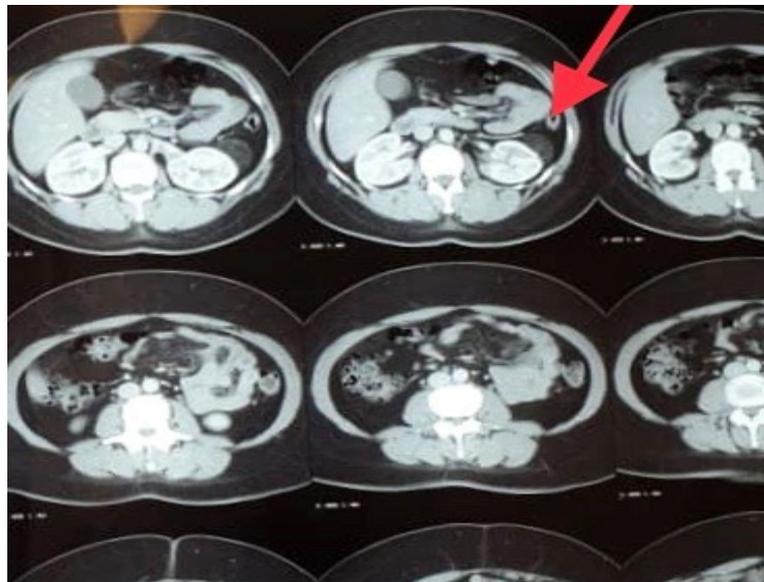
Pre-operation abdomino-pelvic CT-Scan
